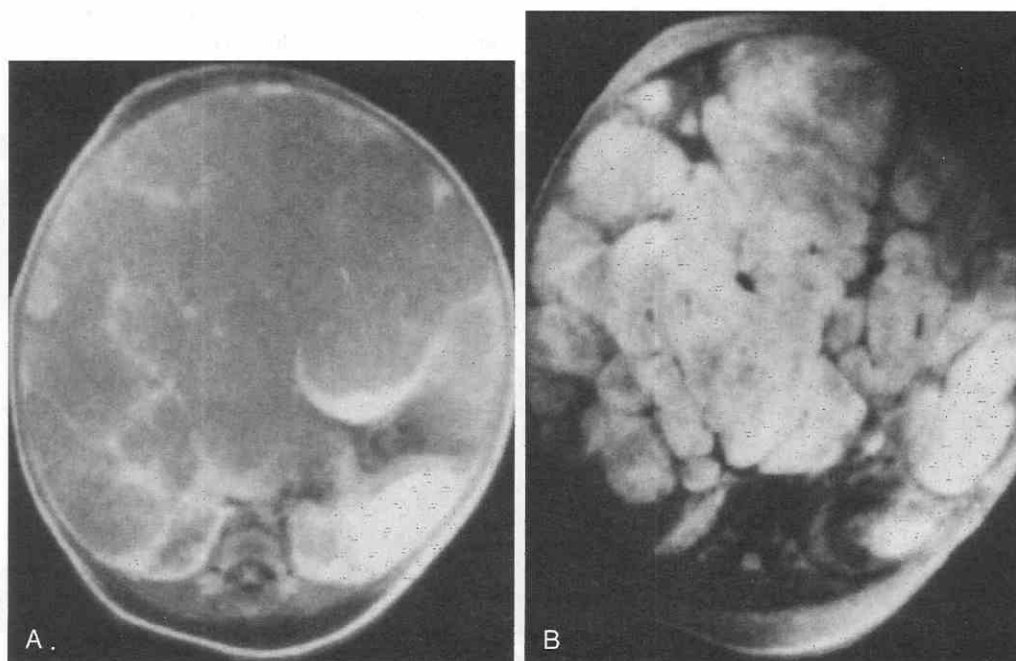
Infantile hemangioendothelioma in an infant girl. *A*, T1-weighted image, obtained with the patient in the decubitus position, reveals a large, multinodular hepatic lesion of heterogeneous signal intensity that fills the abdomen. *B*, T2-weighted image shows that the lesion has predominantly high signal intensity because of its vascular nature.
